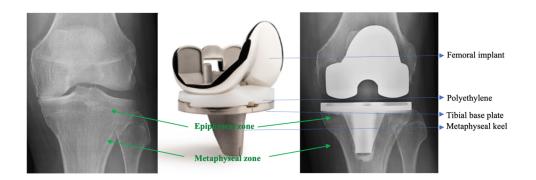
Tibial fixation in primary total knee arthroplasty: on the left a frontal X-ray of knee osteoarthritis, in the middle an image of a total knee arthroplasty and on the right a post operative frontal X-ray of the same type of total knee arthroplasty
